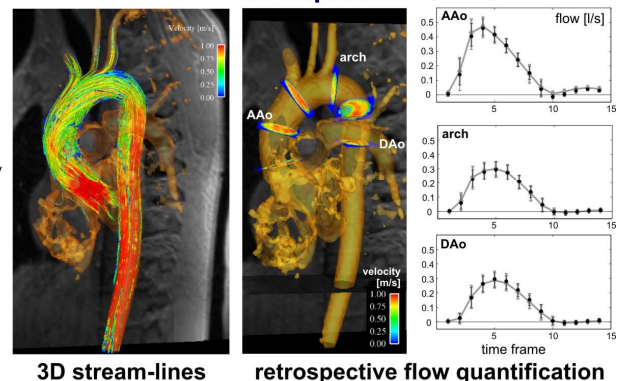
Acquisition of 4D flow MRI data (A) and visualization and quantification of 3D hemodynamics (B) in the aorta. The 4D velocity mapping raw data comprises information along all 3 spatial dimensions, 3 velocity directions and time in the cardiac cycle. A 3D phase contrast angiogram (B, iso-surface rendering of the aorta) can be calculated from 4D flow MRI data to aid visualization and placement of analysis planes for retrospective flow quantification.
